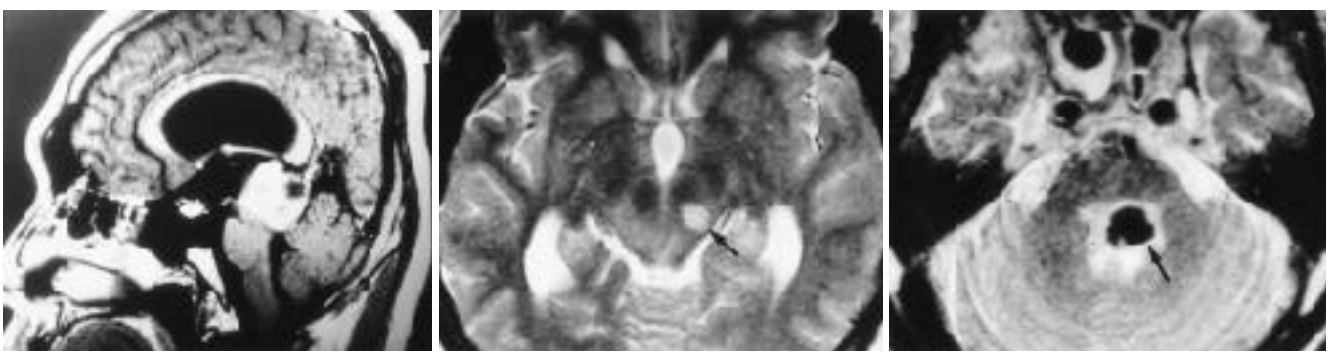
Vertical gaze palsy caused by pineal germinoma (Parinaud 's syndrome) .Enhanced sagittal T1-weighted MR image shows a well enhanced pineal mass which causes compression of the midbrain resulting in patient 's upgaze palsy.
